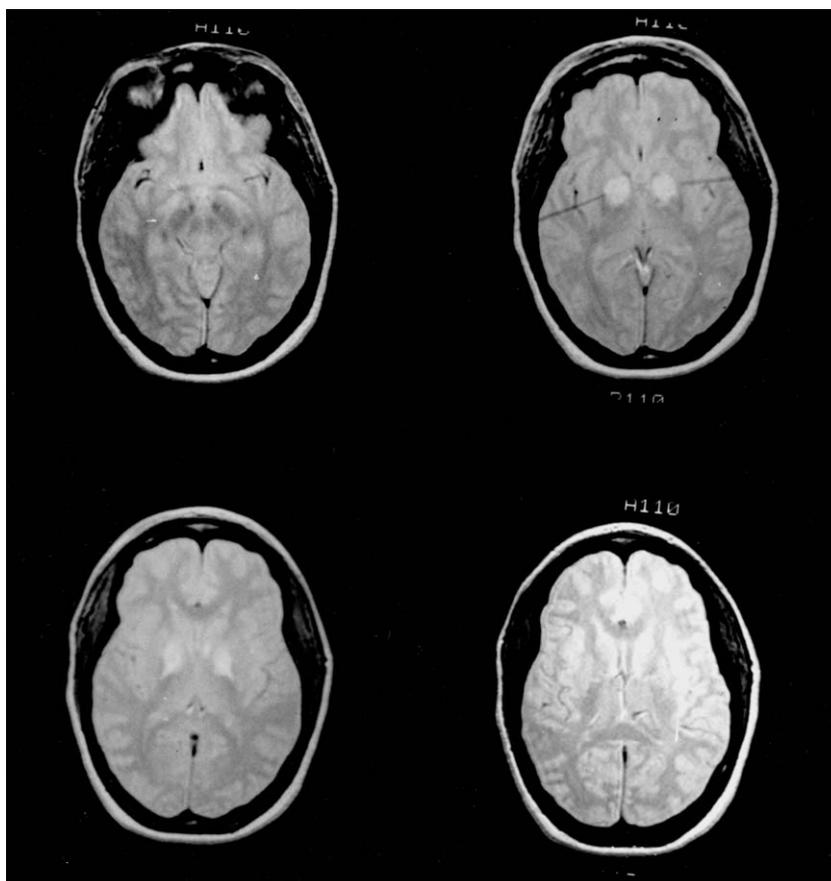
A CT scan of Patient 1 revealed hyperintensity in the globus pallidus and medial putamen bilaterally.
